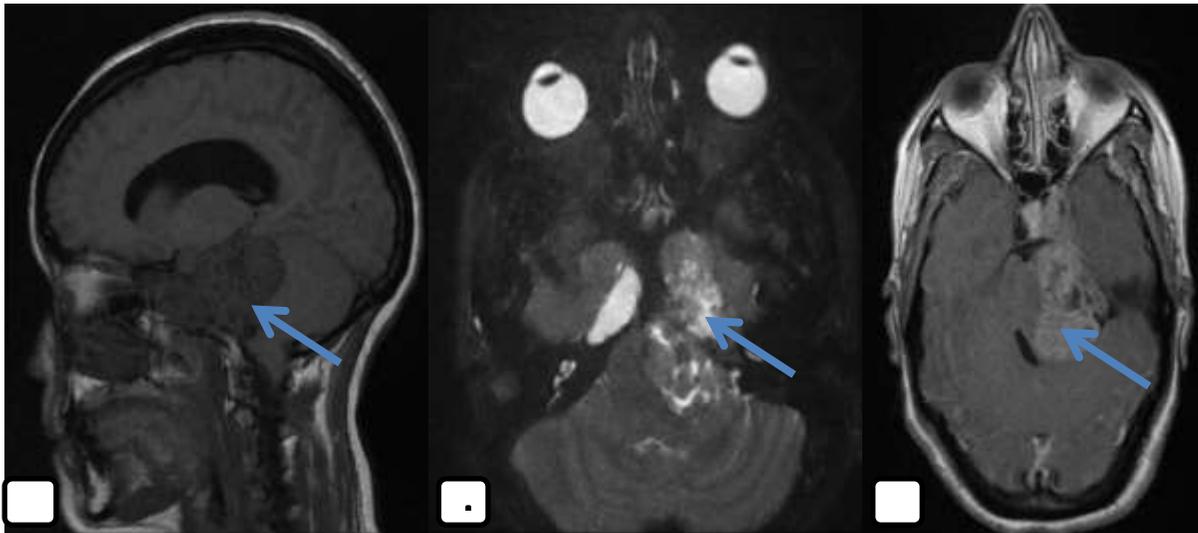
MRI in sagittal section in T1 sequence (a) in axial section in T2 FS sequence (b); in axial section in injected T1 sequence(c): Extra axial expansive lesional process centered on the APC and in left peri-puncture extended to the left latero-sellar region, poorly limited, delineating areas of central liquefaction, the solid area is described in hyposignal T1, moderate hyposignal T2, enhances intensely and heterogeneously after contrast. It invades the IAC, and the homolateral cavernous sinus, backs up the TC with onset of tonsillar involvement, compresses the V3 → Trigeminal schwannoma.
